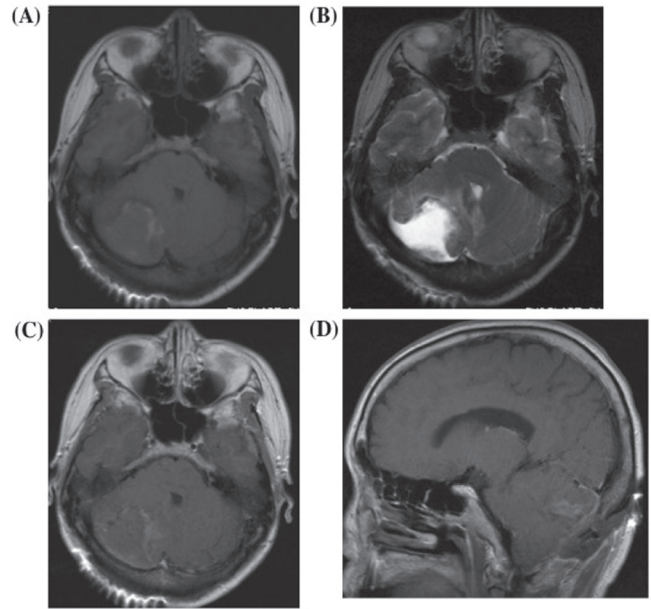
Postoperative T₁-weighted (A) and T₂-weighted (B) magnetic resonance (MR) imaging, and MR image with gadolinium in the axial (C) and sagittal (D) planes, showing that the tumor was completely removed. Note that the brainstem was decompressed and that hydrocephalus had improved.
